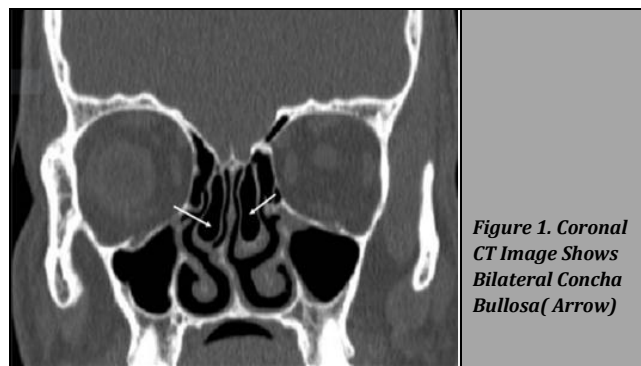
Coronal CT Image Shows Bilateral Concha Bullosa (Arrow)
